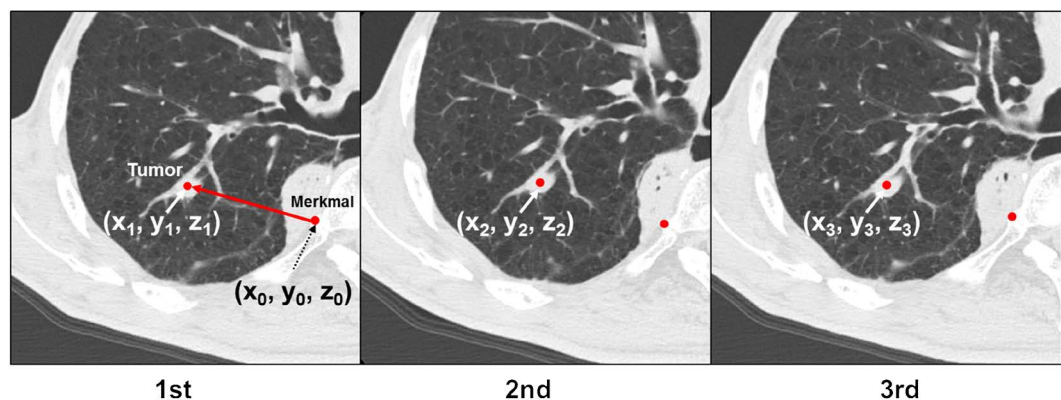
A series of three computed tomography images, ordered 1st, 2nd, and 3rd, demonstrate the same tumor section scanned under breath-holding. To evaluate the reproducibility of breath-holding, the distance between the coordinates of the anatomical landmark (X_0, Y_0, Z_0) and the tumor ($X_{1-3}, Y_{1-3}, Z_{1-3}$) were measured for each image, respectively.
